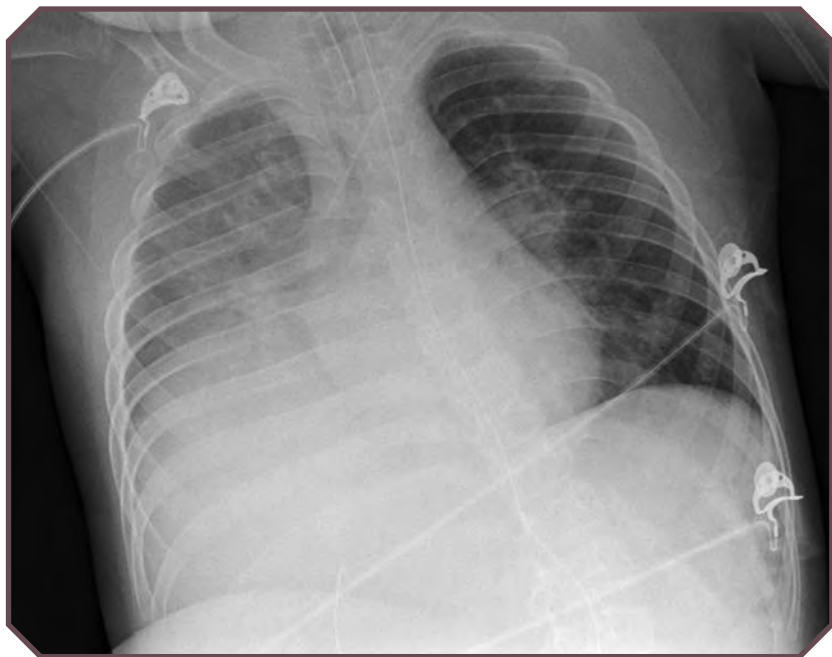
Aspiration due to foreign body in a 3-year-old girl who vomited and aspirated a large volume of gastric material. Frontal chest radiograph shows right lower lobe focal opacity. An endotracheal tube, nasogastric tube, and central line overlie the midtrachea, stomach, and superior vena cava, respectively.
